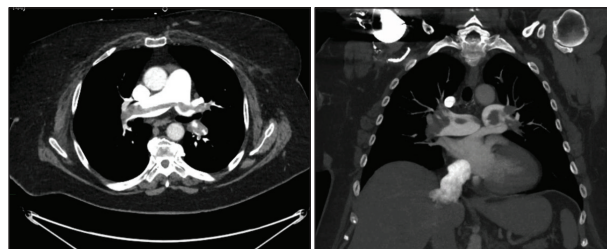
CT scans showing saddle embolus in main PA.
